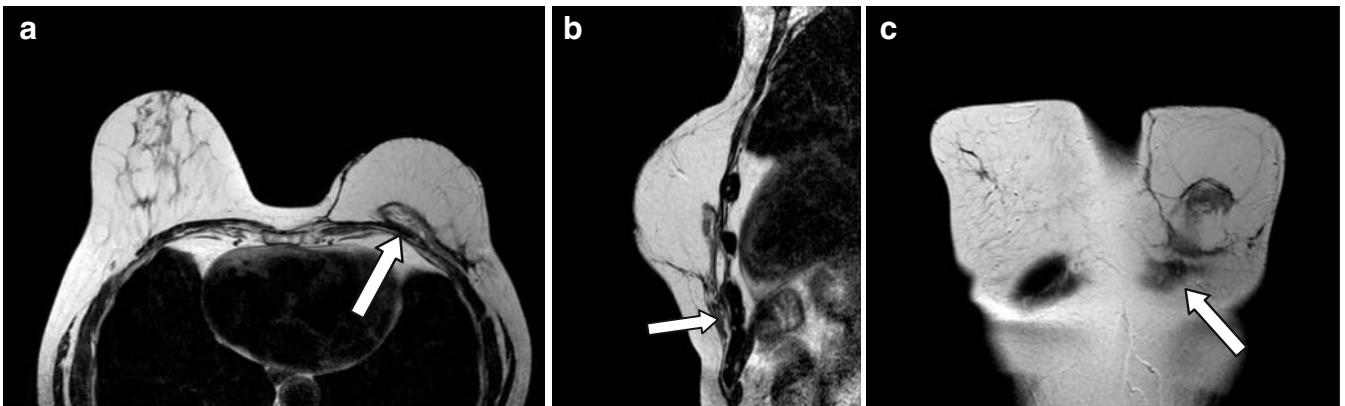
Case number 8640 of March 12th, 2009; 58 year-old patient, left skin sparing mastectomy and TRAM reconstruction flap in 2007; T2-weighted sequences in the transverse (A), sagittal (B) and coronal (C) plans showing the *rectus abdominis* muscle in the posterior portion of the reconstructed breast (white arrows).
